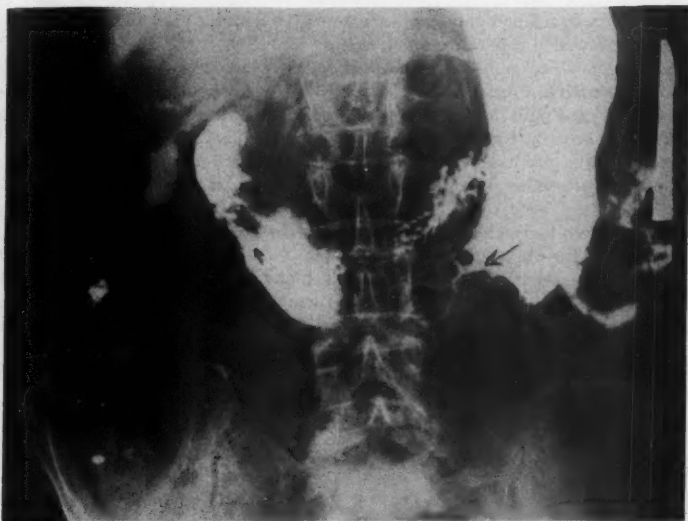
Case 4. Patient 67 year old man who had a discrete adenomatous polyp removed from his stomach 8 years previously; the base of polyp had not been removed. Roentgenogram demonstrating polypoid carcinoma of the greater curvature of the stomach with numerous small polyps in surrounding area.
